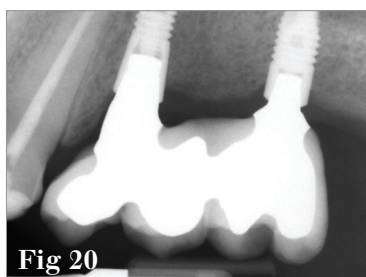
Baseline radiographs
